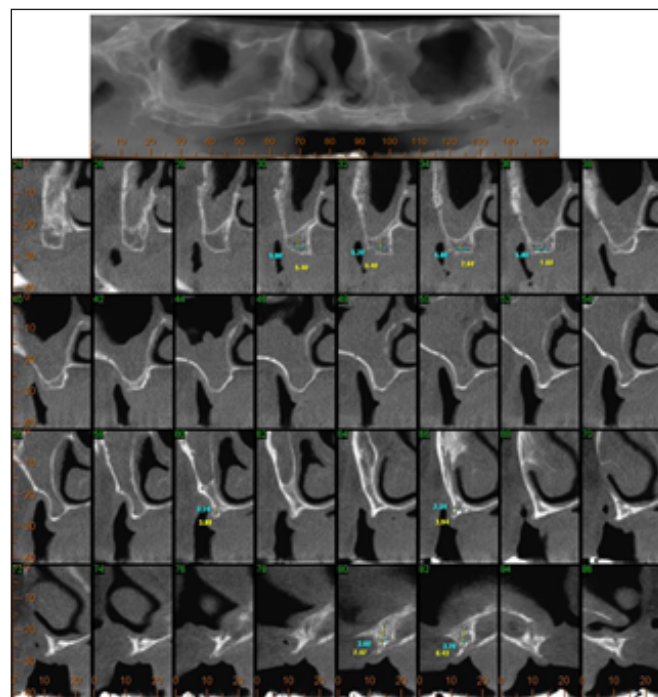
Cone beam computerized tomography (CBCT). The CBCT presented showing the pre surgical class VI atrophic maxilla.
